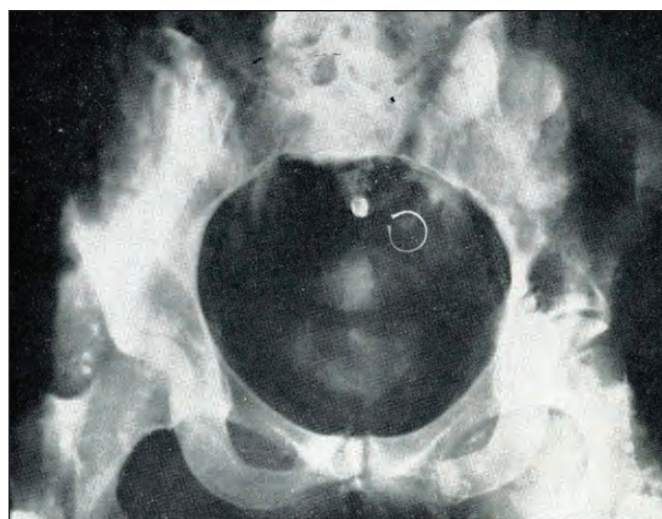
Example of X-ray findings in a victim of mass disaster of our casuistry.
